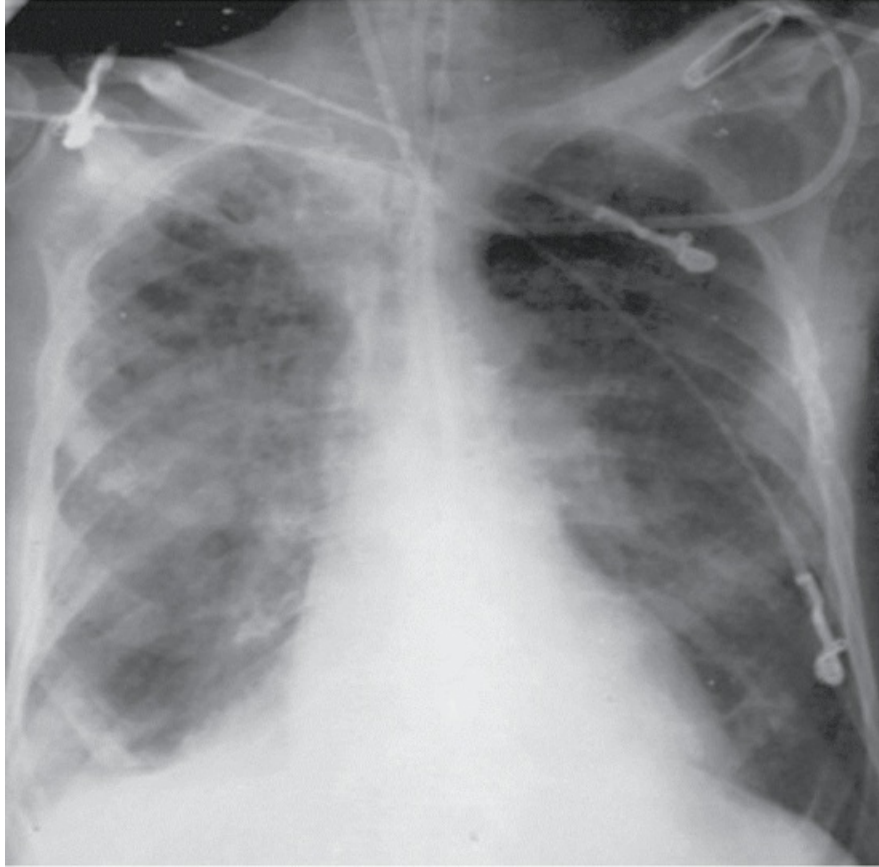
Posteroanterior chest radiograph of a patient with extensive Gram-negative bronchopneumonia. Note the patchy infiltrates throughout both lungs, which are more prominent on the right.
